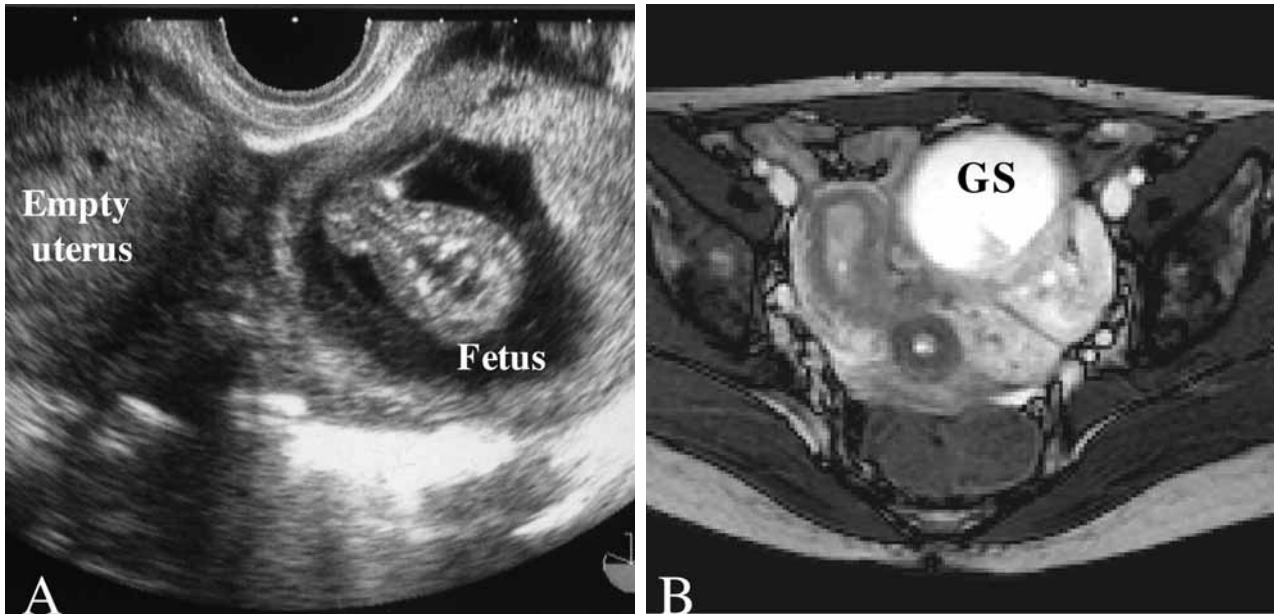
Transabdominal ultrasonographic view of a left cornual pregnancy (A), and magnetic resonance imaging finding of a left cornual pregnancy on axial T2-weighted images (B).
